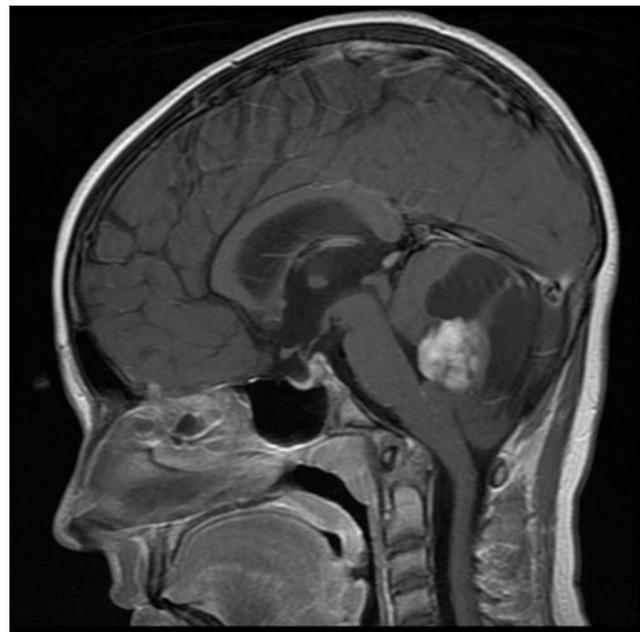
Magnetic resonance imaging of the brain of a 10-year-old with von Hippel-Lindau disease. On this sagittal T1-with-contrast sequence, a posterior fossa hemangioblastoma is present, with the characteristic cystic component and enhancing mural nodule.
